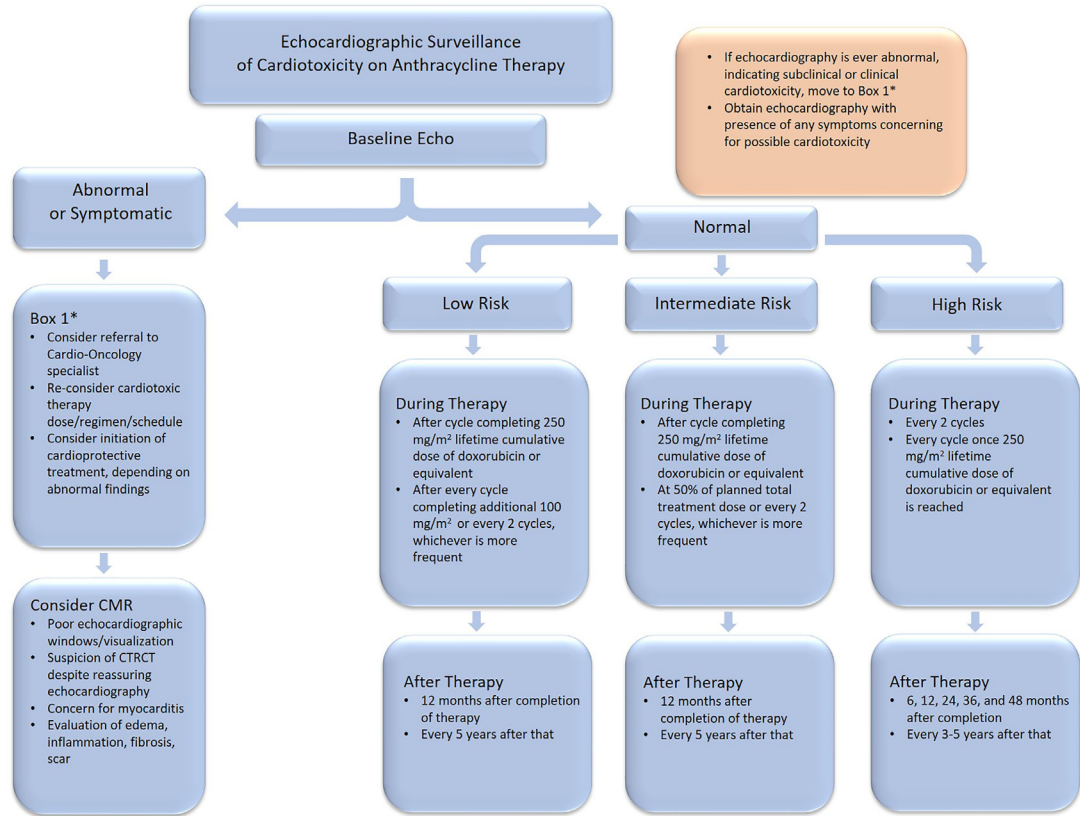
Suggested echocardiographic surveillance protocol of cardiotoxicity in patients on anthracycline therapy. Low risk features include age 18 to 50 years, cumulative dose less than 200 mg/m² doxorubicin (or equivalent), no preexisting or new CVD risk factors. Intermediate features include age 50 to 65 years, cumulative dose 200 to 400 mg/m² doxorubicin (or equivalent), 1 to 2 preexisting or new CVD risk factors. High-risk features include age less than 18 or greater than 65 years, cumulative dose greater than 400 mg/m² doxorubicin (or equivalent), any combination of cardiotoxic cancer therapies, underlying CVD, history of CTRCT. CAD, coronary artery disease; CMR, cardiovascular magnetic resonance imaging; CTRCT, cancer therapy-related cardiotoxicity; CVD, cardiovascular disease; Echo, echocardiography; mo, month.
